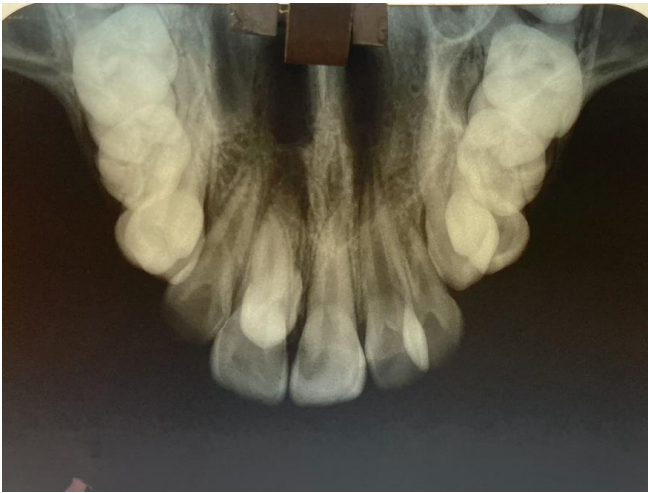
Maxillary Occlusal radiograph
